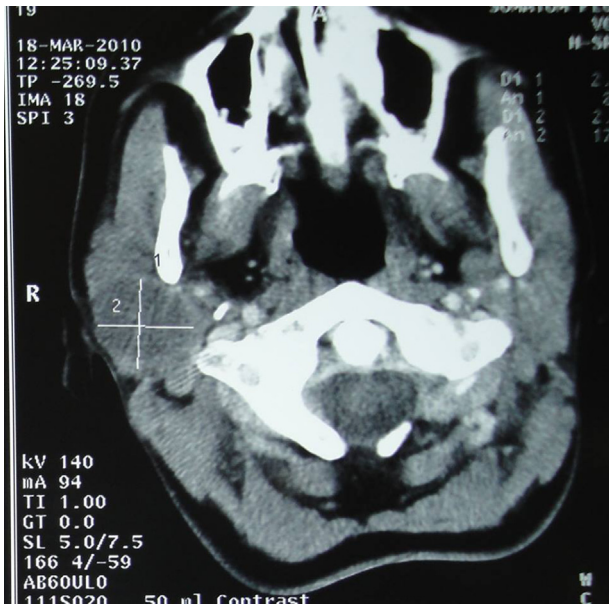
Axial CT scan showing a right parotid gland pleomorphic adenoma with well circumscribed, well-defined margin.
